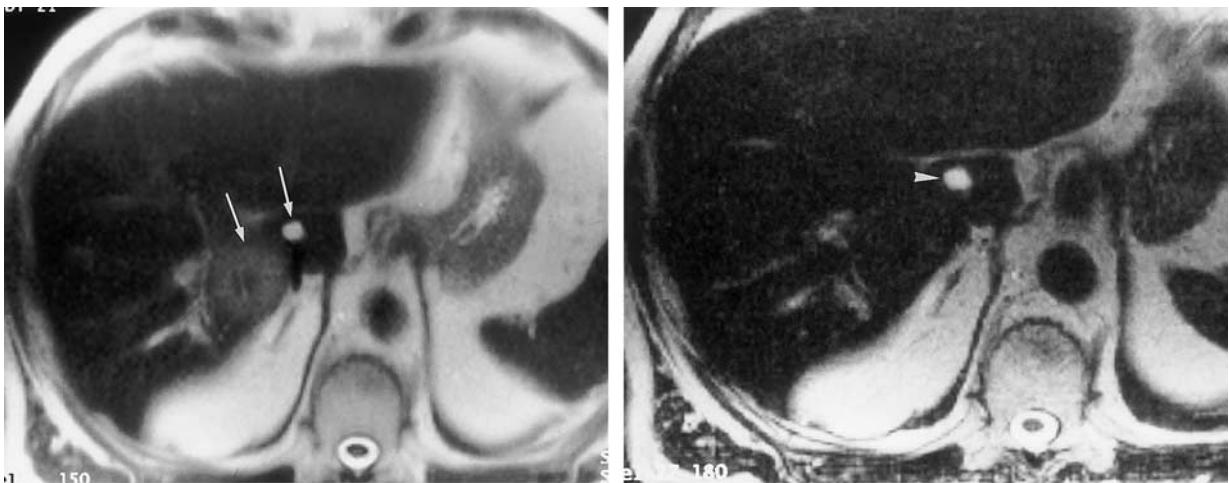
Hepatic cyst in a patient with a history of colon carcinoma. (a) Fast spin-echo T2-weighted MR image shows two high-signal-intensity lesions (arrows) in segment 1 of the liver. (b) Heavily T2-weighted MR image (effective echo time, 166 msec) shows that only the smaller lesion (arrowhead) continues to have the signal intensity of fluid. Therefore, the larger lesion represents a metastasis and the smaller lesion represents a simple bile duct cyst.
